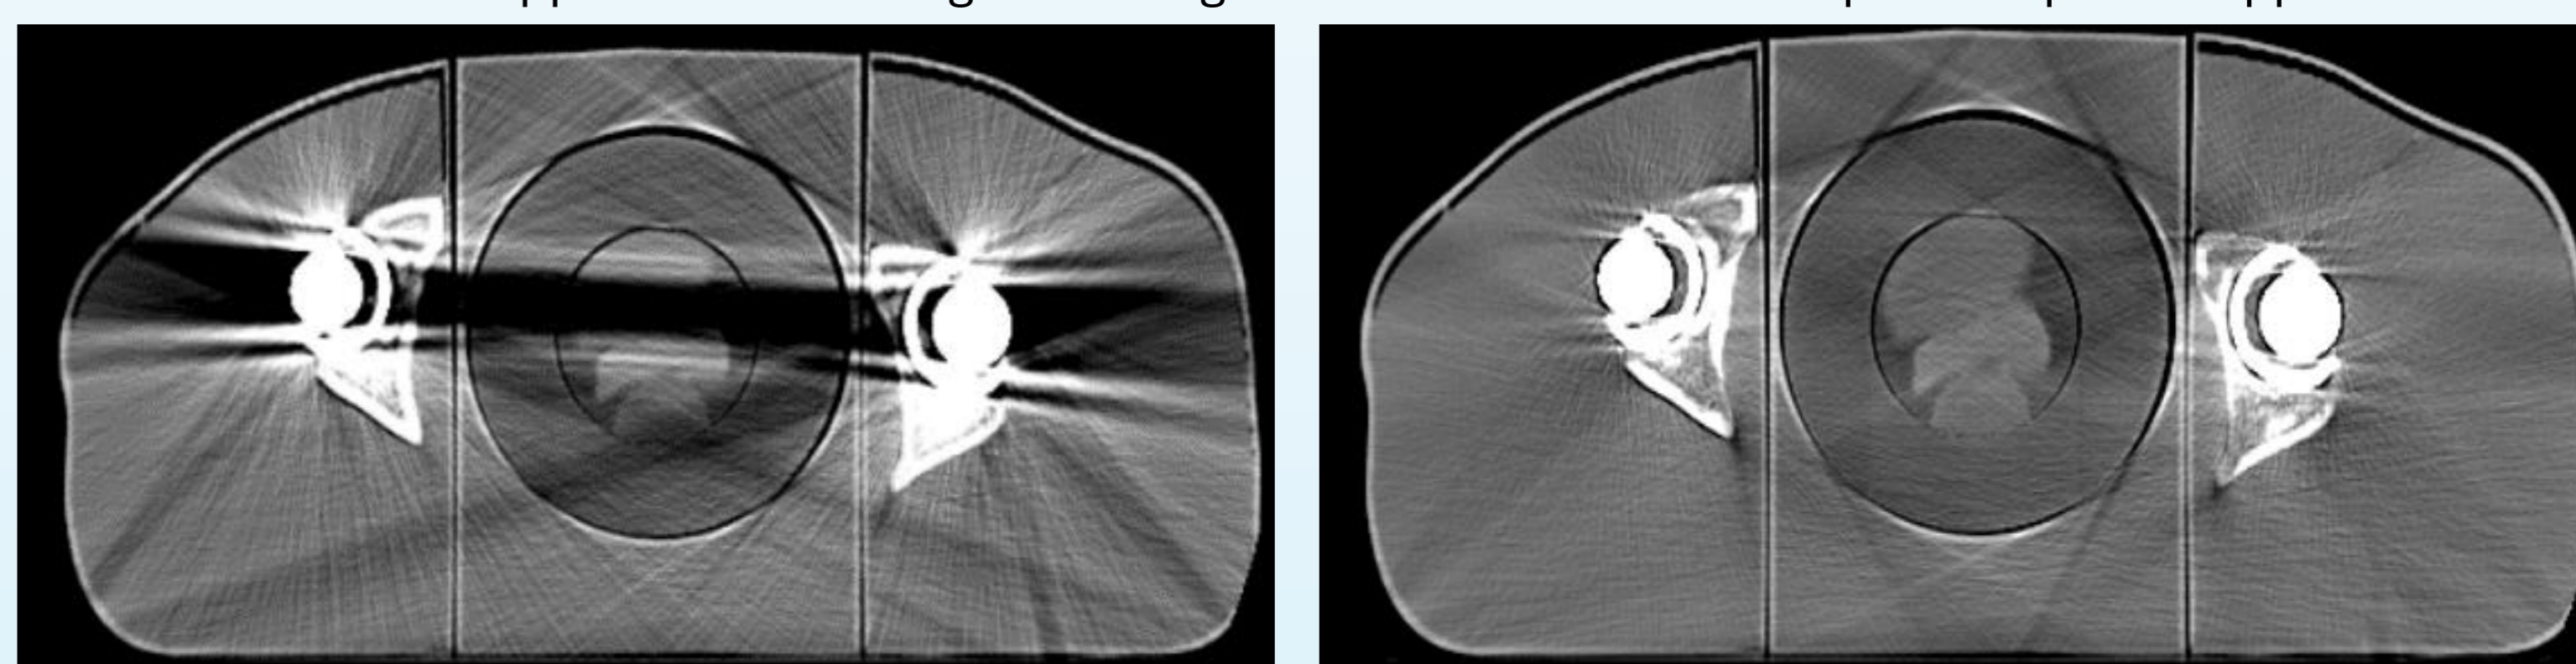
Image on the left shows the CT image of bilateral hip implant set up with the 3D printed organs and, on the right, shows the same CT image reconstructed using Hip iMAR
